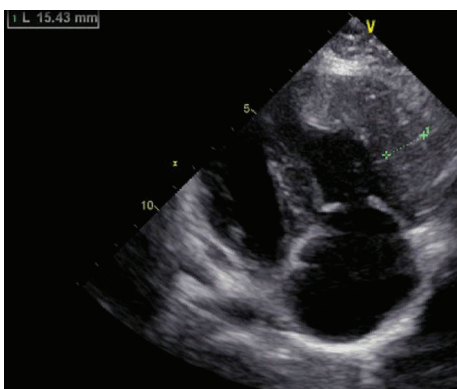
Right ventricular view on echocardiography. In echocardiography, the right atrium was dilated and RV was extremely hypertrophic. RV free wall thickness was measured as 15.4 mm.
